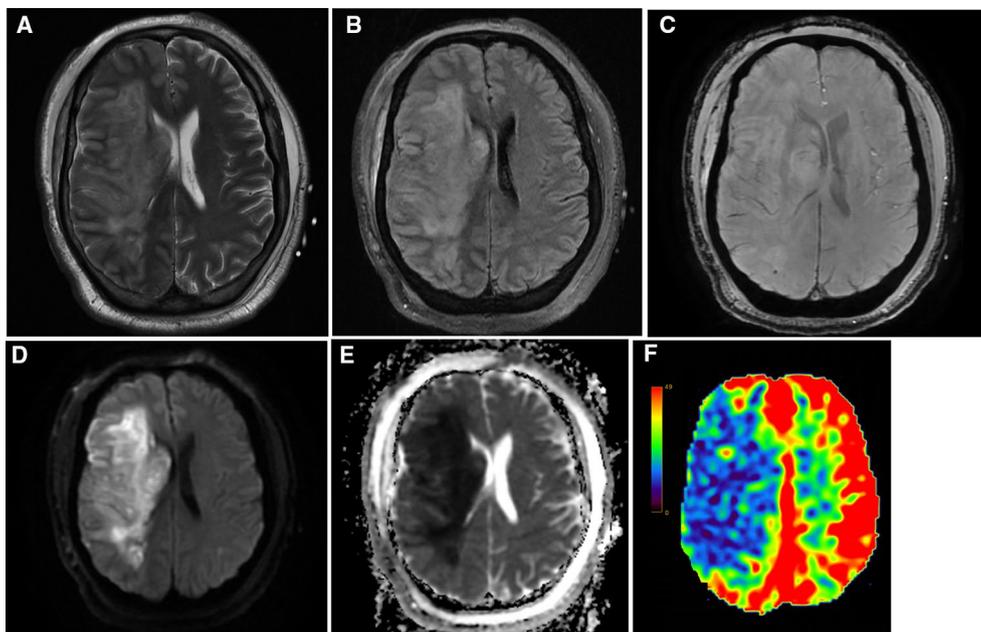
Acute infarction with no ischemic penumbra: 75 years old female patient complaining of left hemiplegia since 10 h. A T2WI, B FLAIR, C SWI, D DWI, and E ADC map show acute ischemic infarct at the right frontoparietal region along the territory of the right MCA. ASPECTS score was 3/10. F ASL perfusion at 1.5 s shows corresponding area of hypo perfusion (no diffusion perfusion mismatch) without ischemic penumbra, $aCBF = 11 \text{ mL/gm } 100/\text{min}$ — $rCBF = 62\%$ to contra lateral side. $aCBF$ absolute cerebral blood flow, ADC apparent diffusion coefficient, ASL arterial spin labeling, $ASPECT$ Alberta Stroke Program Early CT Score, DWI diffusion weighted image, $rCBF$ relative cerebral blood flow, SWI susceptibility weighted image
